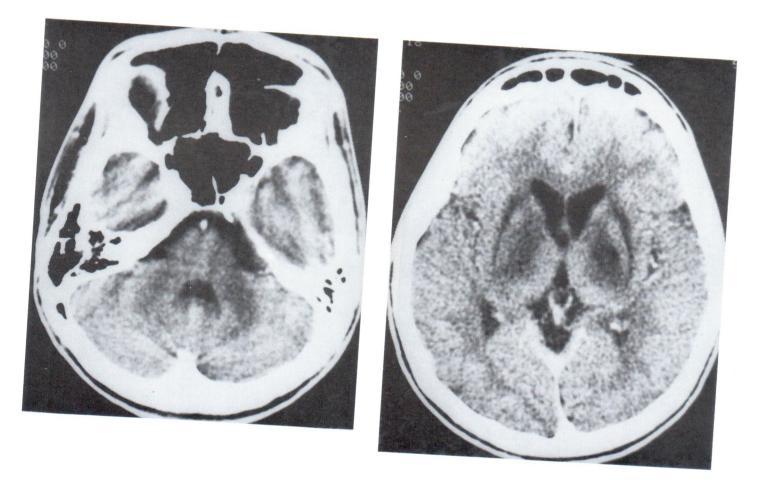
Case 1. The 2nd CT scan on July 22, 1988 showed a new low density lesion in the left cerebellum. Larger lesions at pons, thalamus, putamen, internal capsules was noted without increasing size of the ventricles.
